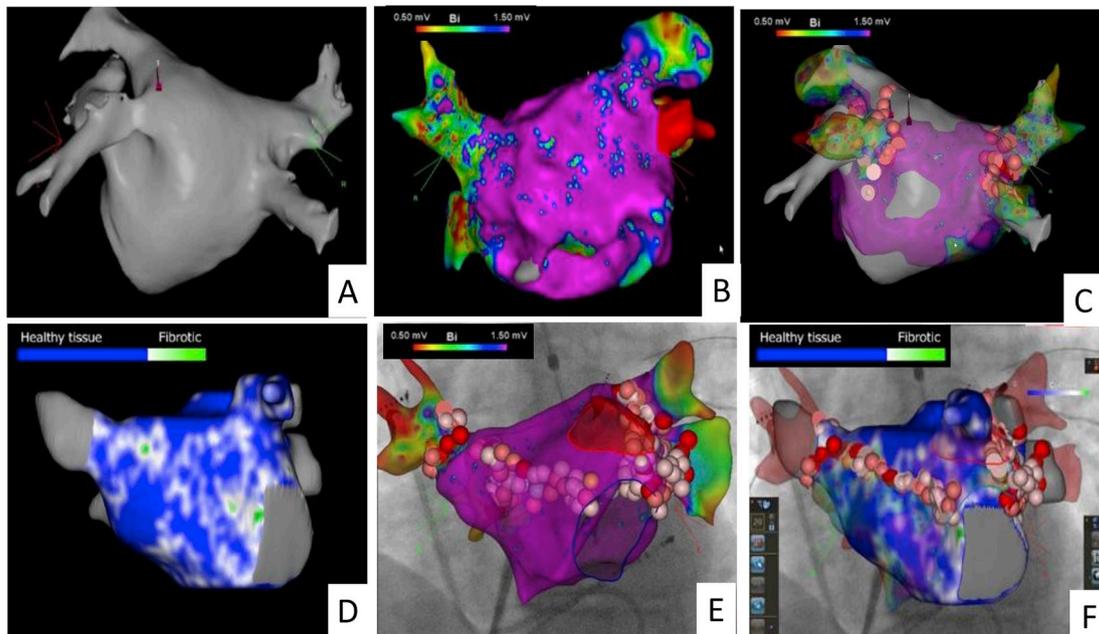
A. CCT 3D volume rendering of left atrial volume. B. 3D electroanatomical mapping of left atrium. C. 3D CCT volume and 3D electroanatomical mapping merge. D. Left atrial 3D color model of segmented delayed enhancement CMR scan for left atrial fibrosis. E. 3D electroanatomical mapping F. Left atrial 3D color model of segmented delayed enhancement CMR scan for left atrial fibrosis and 3D electroanatomical mapping merge. CCT: cardiac computed tomography; CMR: cardiac magnetic resonance.
